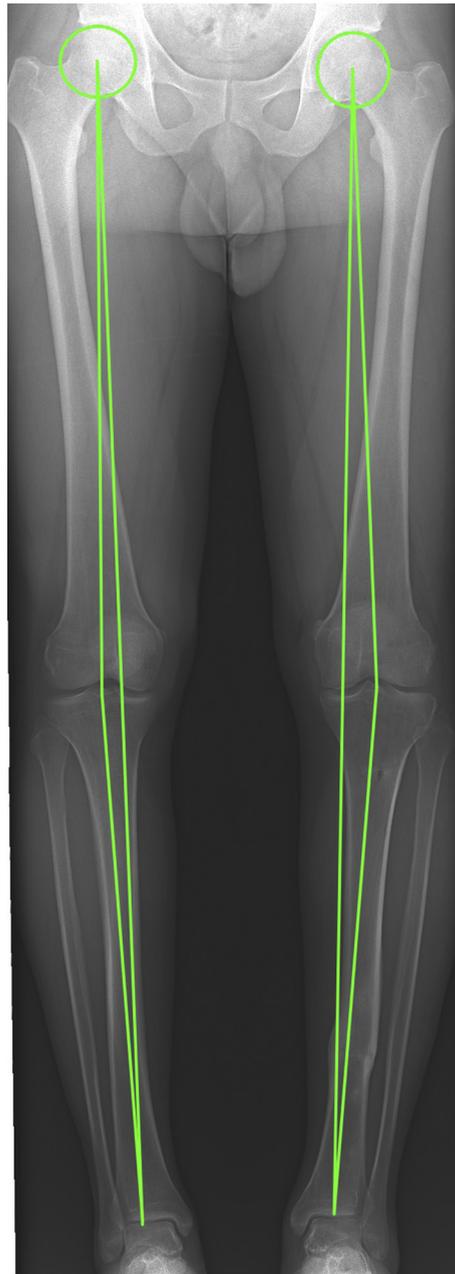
Pre-operative panoramic weight-bearing radiograph of the lower limbs of a patient undergoing valgus osteotomy and multiligament reconstruction.
